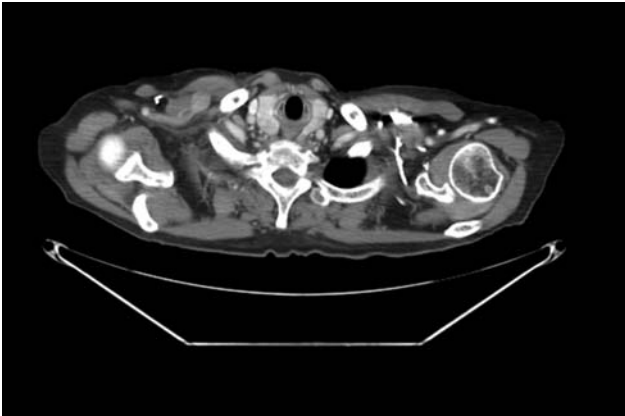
CT scan with the right subpectoral lymph node.
